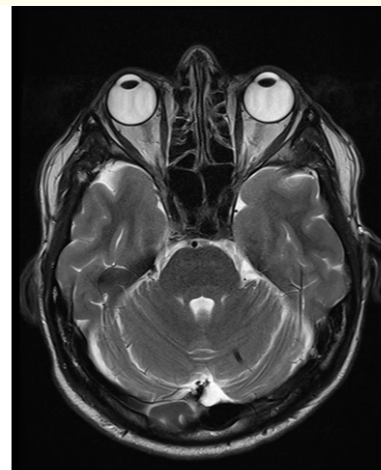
An MRI was performed to rule out demyelinating diseases. The analysis of the images showed no alterations.
